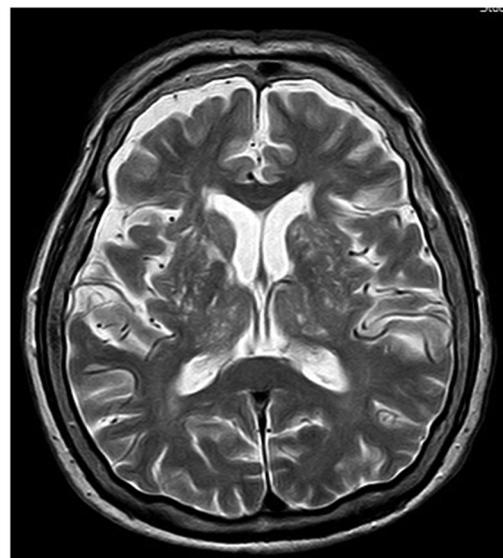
T2-weighted MRI of a study participant with massively enlarged basal ganglia perivascular spaces bilaterally.
